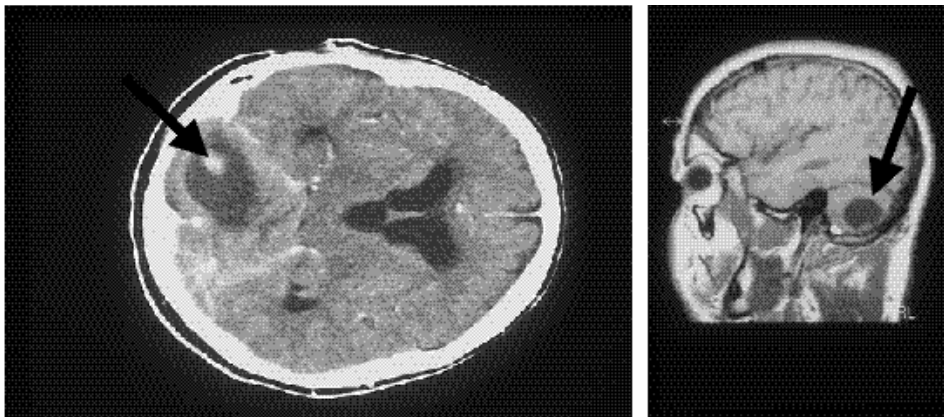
Comparison of MRI (left) and CT (right) of a typical haemangioblastoma in a VHL patient. Both arrows indicate a cystic lesion with a solid lesion attached to the wall. This lesion is also called nidus (i.e. Latin for nest) since the image resembles a bird's nest with an egg.
